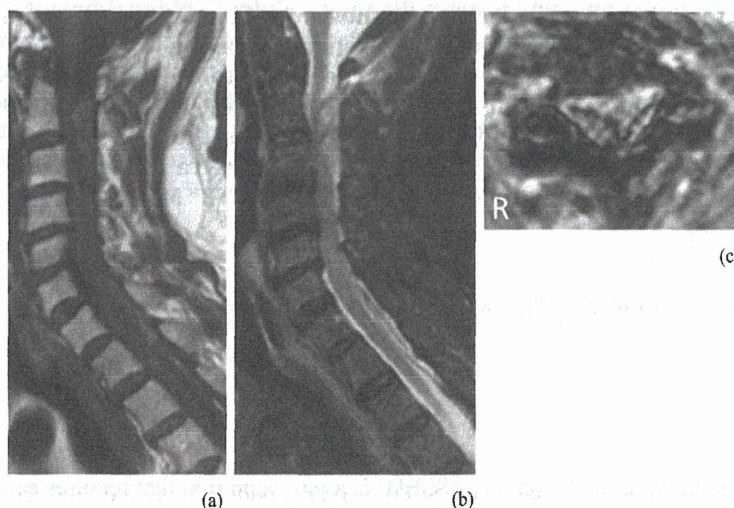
(a) A dorsal extradural lesion at the C2-Th3 level, which was iso/hyperintense to the cord on T1-weighted images (b) iso/hyperintense with a band of hypointensity on T2-weighted images (c) hypointensity spots within a hyperintensity mass with a clear hypointense rim on T2* MRI.
